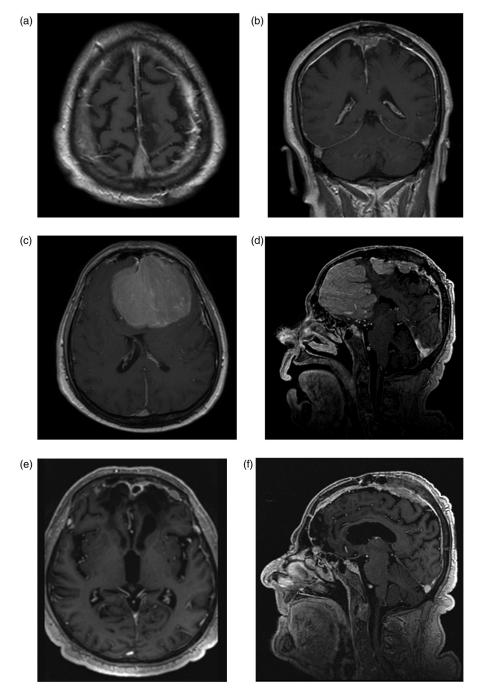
Post-contrast MRI of a 72-year-old man who underwent resection of the 2.5 cm WHO II meningioma of the left middle parasagittal region and stereotactic radiosurgery in 2012. (a, b) MRI in 2015: residual tumor in the middle third of the superior sagittal sinus; (c, d) Post-contrast MRI in May 2018: very diffuse recurrence with a large tumor of the anterior third of the falx and smaller nodules of the left side of the falx anterior to the previous surgical field; (e, f) Post-contrast MRI in December 2018: gross total resection of both intradural meningiomas; residual extensive infiltration of the superior sagittal sinus and falx.
